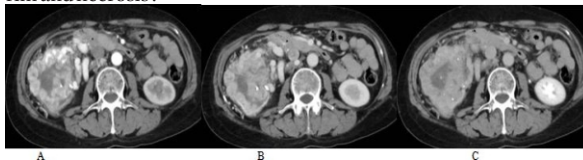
A 51-yr female patient. The Triphasic CT shows a large CCC in the right kidney with marked and heterogeneous enhancement, central necrosis classifications and unclear rim. Notice so many tortuous collateral vessels around the mass.
